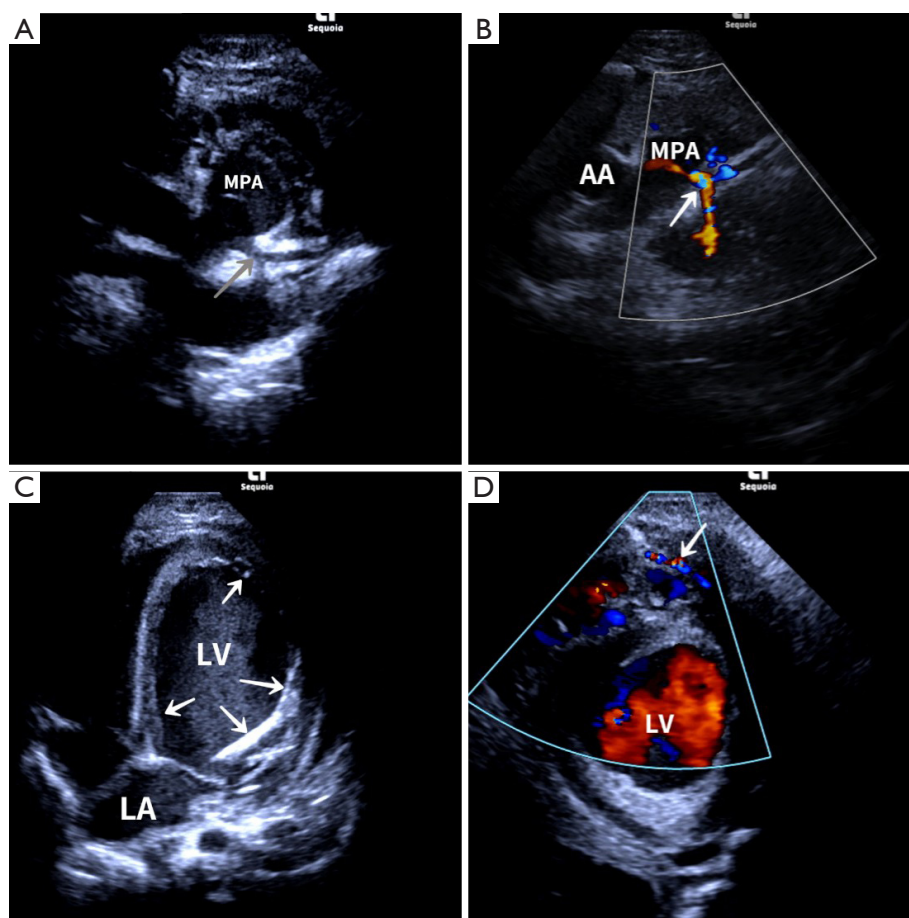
Echocardiographic imaging of infant type anomalous left coronary artery arising from the pulmonary artery. (A) A parasternal view shows the left coronary artery of abnormal origin (grey arrow). (B) A color Doppler echocardiographic image reveals reversed flow (red color) in the left coronary artery (white arrow) in a case of infant-type anomalous left coronary artery arising from the pulmonary artery. (C) An apical four-chamber echocardiogram shows the echogenic valve structure and endocardium with ischemic damage-induced fibrosis (white arrows). (D) An apical short-axis echocardiographic image demonstrates characteristic inter-coronary collateral arteries (arrow) in the apex. Notably, the left atrium and left ventricle are enlarged. MPA, main pulmonary artery; AA, ascending aorta; LA, left atrium; LV, left ventricle.
